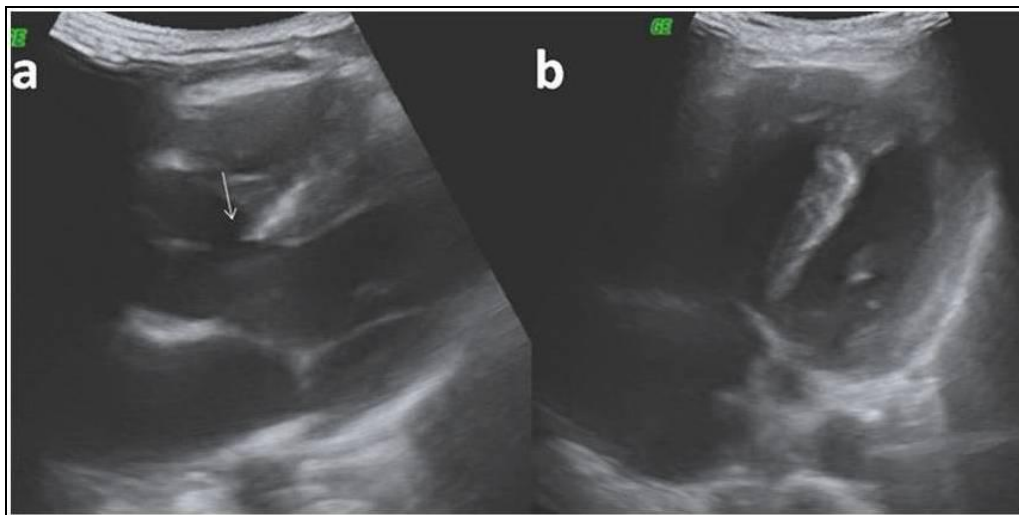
ECHOCARDIOGRAPHY OF THE PATIENT SHOWS VENTRICULAR SEPTAL DEFECT (a) AND RIGHT VENTRICULAR HYPERTROPHY
